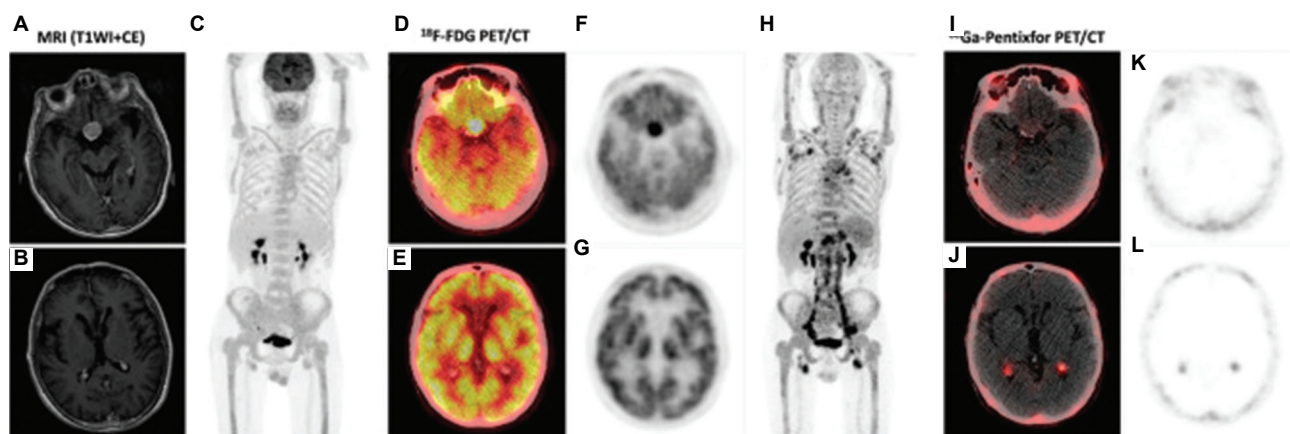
Baseline and comparative PET/CT evaluation in a 63-year-old man with Waldenström's macroglobulinemia and biopsy-confirmed Bing-Neel syndrome. (A and B) Axial contrast-enhanced T1-weighted MRI shows a pituitary macroadenoma without other intracranial abnormalities. (C and D) The MIP image of the ^{18}F -FDG PET shows diffuse homogeneous bone marrow uptake and multiple nodal involvements (C), while axial fusion and PET images reveals intense FDG uptake in the pituitary macroadenoma (SUV_{max} 10.4; white arrows) (D-G). (H-L) In contrast, ^{68}Ga -Pentixafor PET MIP demonstrates avid skeletal and nodal disease with additional tracer uptake in the bilateral choroid plexus (SUV_{max} 4.0; yellow arrows) (H), as confirmed by fusion and PET images (I-L). Notably, the pituitary macroadenoma exhibits no ^{68}Ga -Pentixafor uptake, indicating absent CXCR4 expression. This figure is adapted from Pan *et al.*,⁴⁹ available under a Creative Commons Attribution (CC BY 3.0) license.
